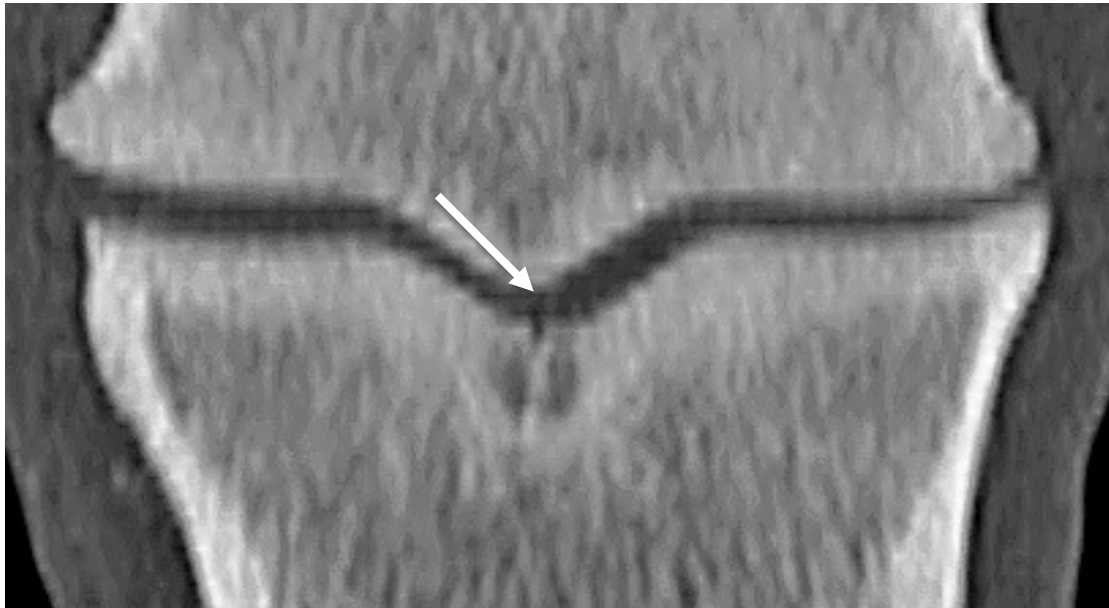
Dorsal CT view of the same lesion within the proximal sagittal aspect of P1. There is a split-like crack (arrow) within the sagittal groove.
